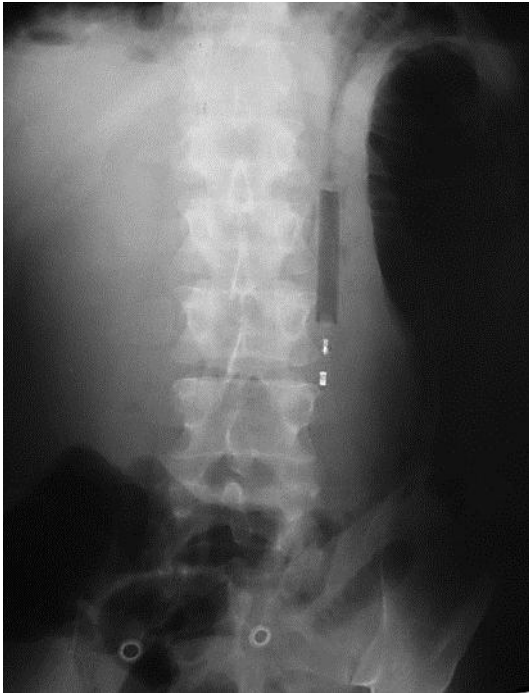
Plain X-ray showing a rectangular partly radiopaque, partly radiolucent object measuring 8.5×1 cm, situated in the paravertebral middle abdomen slightly to the left. The findings indicated a foreign body in the stomach.
